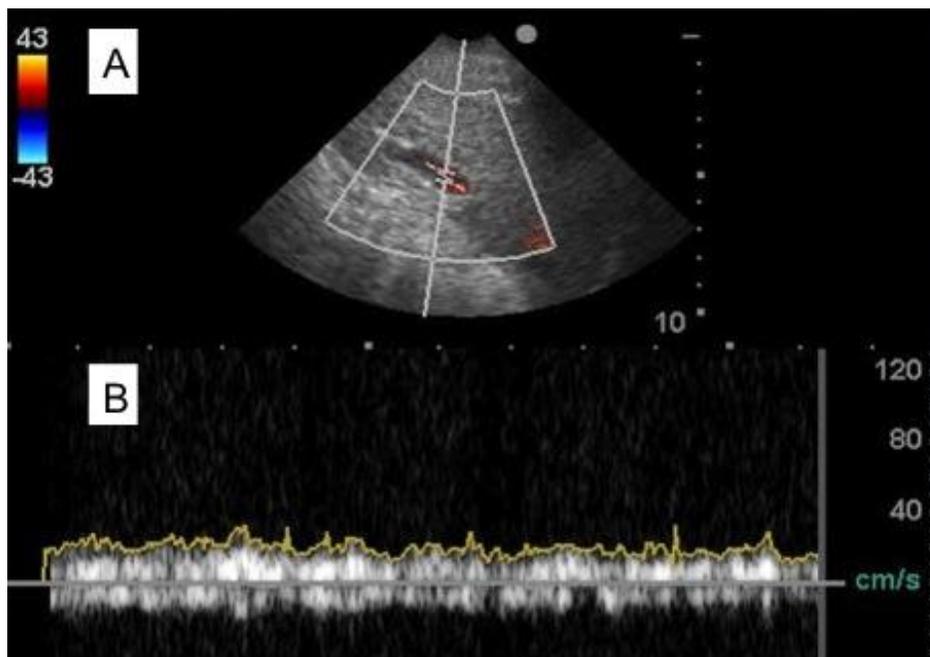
Hepatic portal vein image in Color Doppler ultrasonography (A) and below is a non-pulsatile vein waveform (B)
